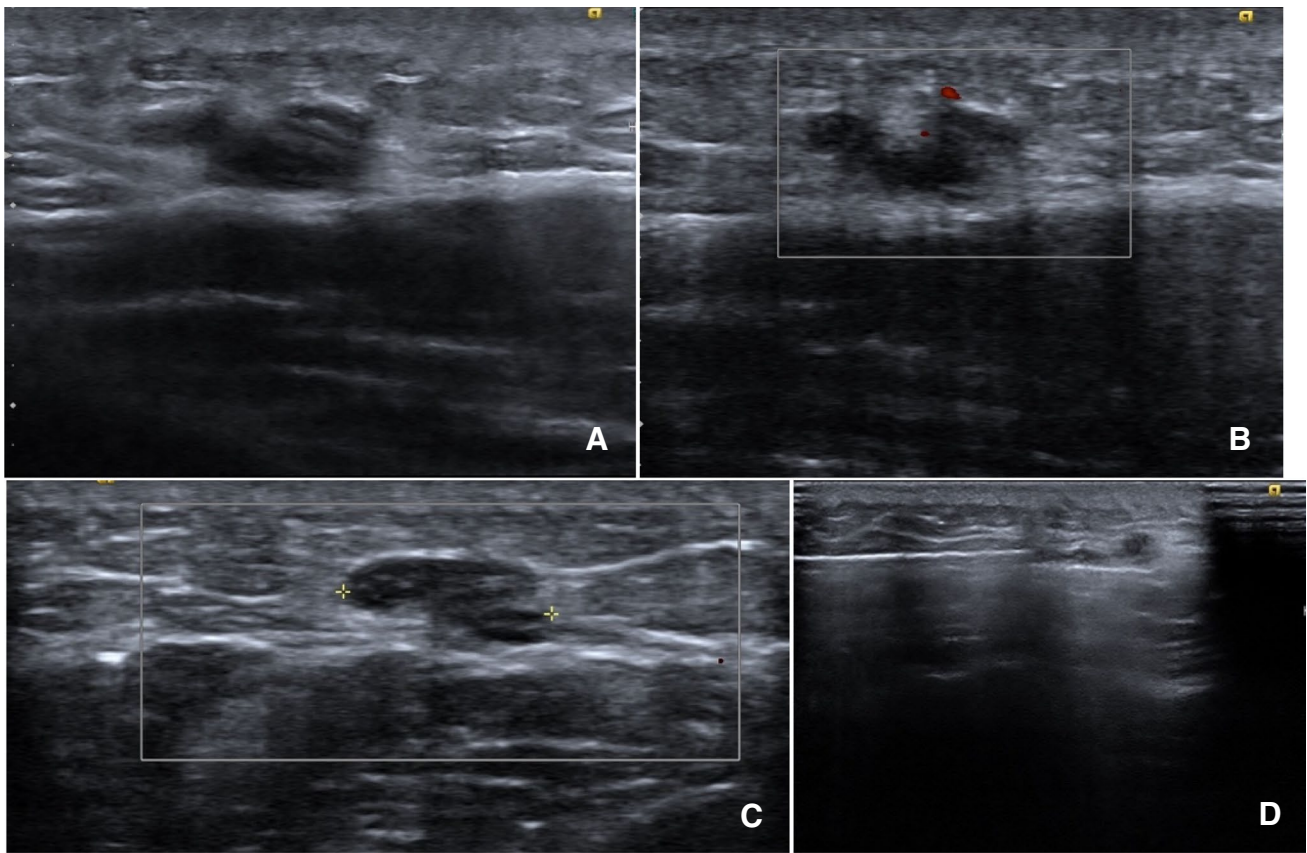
Ultrasound of left upper arm. a Longitudinal grayscale ultrasound, b Longitudinal color Doppler ultrasound, c Transverse color Doppler ultrasound, d Ultrasound guided biopsy of left lateral upper arm
